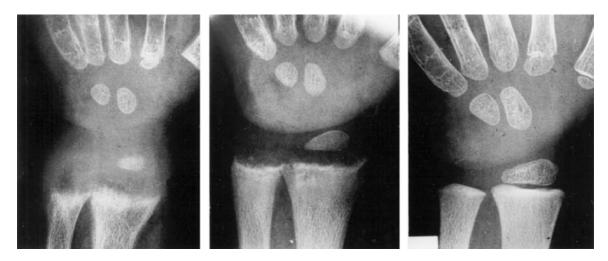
Radiographic changes of rickets. Note the progressive improvement in the radiographic picture from left to right in response to vitamin D treatment over a period of 3 months. (Reproduced with permission from Pettifor JM Calcium, phosphorus and vitamin D. In: Clinical Nutrition of the Young Child, vol 2. (A Ballibriga, O Brusner, J Dobbings *et al.* eds.), 1994 Copyright © New York/Vevey: Raven Press/Nestec Ltd.)
